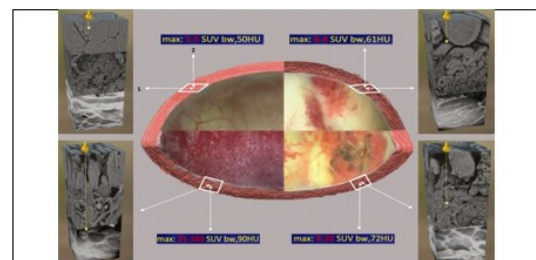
Clinical navigation scheme of the probable 3D cystoscopic view of the mucosa and the 3D ultrastructural condition of the bladder wall's barrier functions at $6000\times$ magnification, based on the digital standardized uptake value (SUV) of ^{11}C -choline from PET/CT results.
